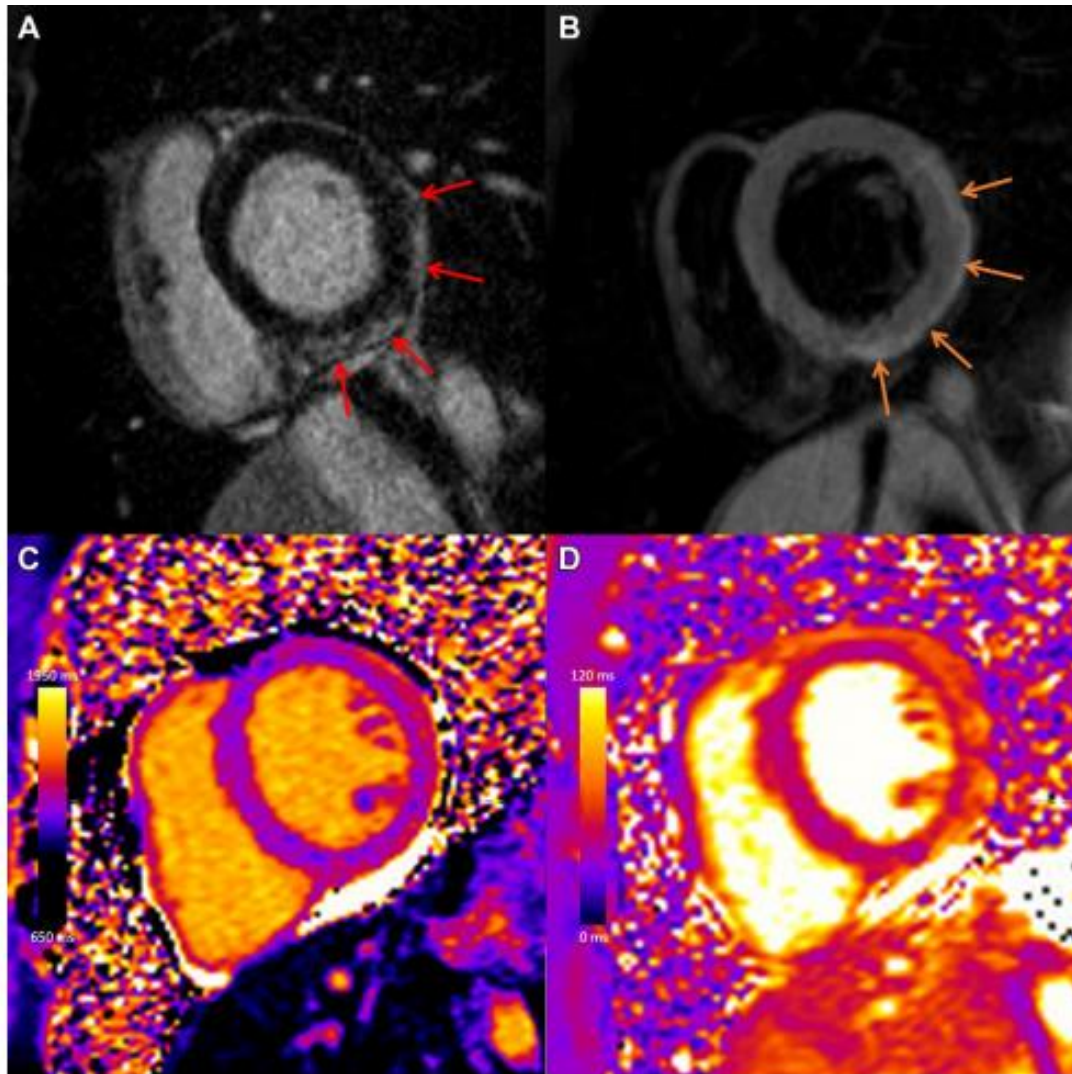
Case example in a 31-year-old man with viral myocarditis. Initial cardiac MRI performed at 3 T within 1 week of symptom onset demonstrates (A) subepicardial to nearly transmural late gadolinium enhancement (LGE) at the basal to mid anterior lateral, inferior lateral, and inferior wall (red arrows) with (B) corresponding high T2 signal, in keeping with edema (orange arrows), (C) high regional native T1 (1480 msec), and (D) high regional native T2 (56 msec) on short-axis images. Images from follow-up cardiac MRI performed at 1.5 T 5 months later demonstrate contraction of subepicardial LGE at the basal to mid inferior lateral and inferior wall (E) red arrows) with (G) corresponding high regional native T1 suggestive of fibrosis (1305 msec) and (F) resolution of edema with no corresponding high T2 signal and (H) normalization of T2 mapping values (46 msec).
